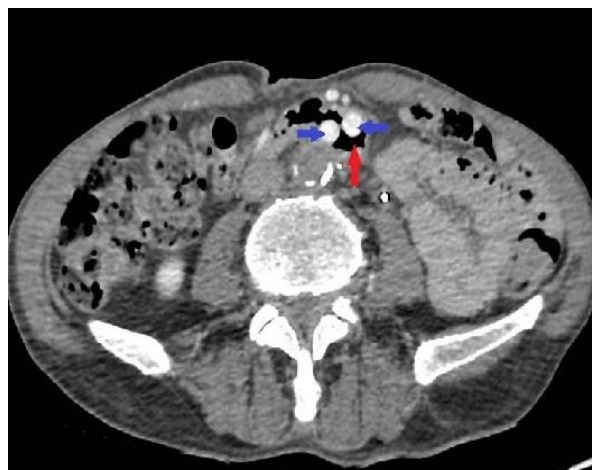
Computed tomography image shows ectopic gas (red arrow) adjacent to the left and right segment of the graft (blue arrows)
